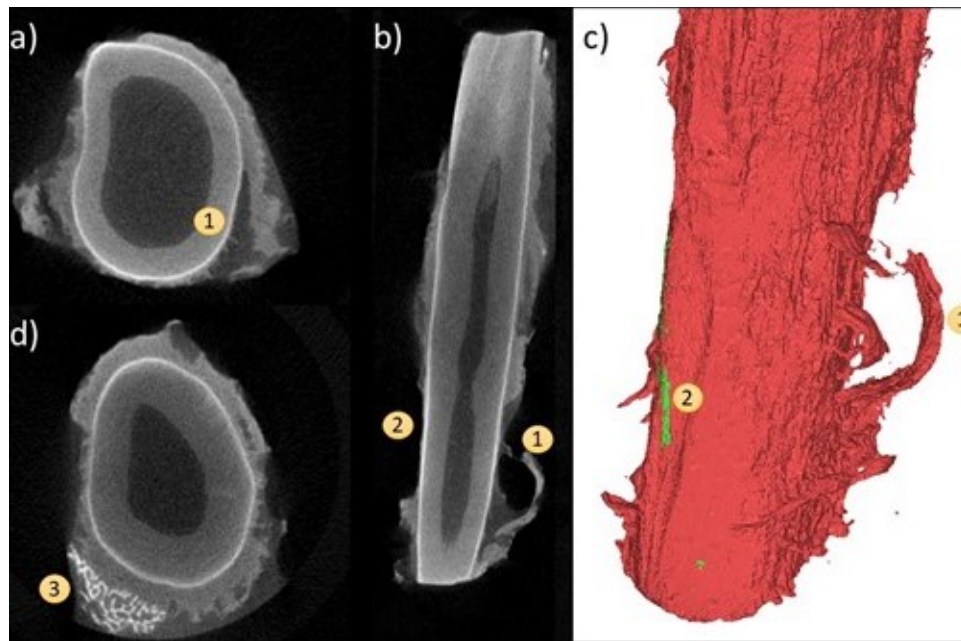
Coronal (a), frontal (b), and 3D reconstruction views (c) of a “flap” pattern of PDL rupture (1) observed with CE- μ CT. Opposite is an area of root denudement without a flap (2); A coronal view near the apex (d) showing a small fragment of attached bone (3).
